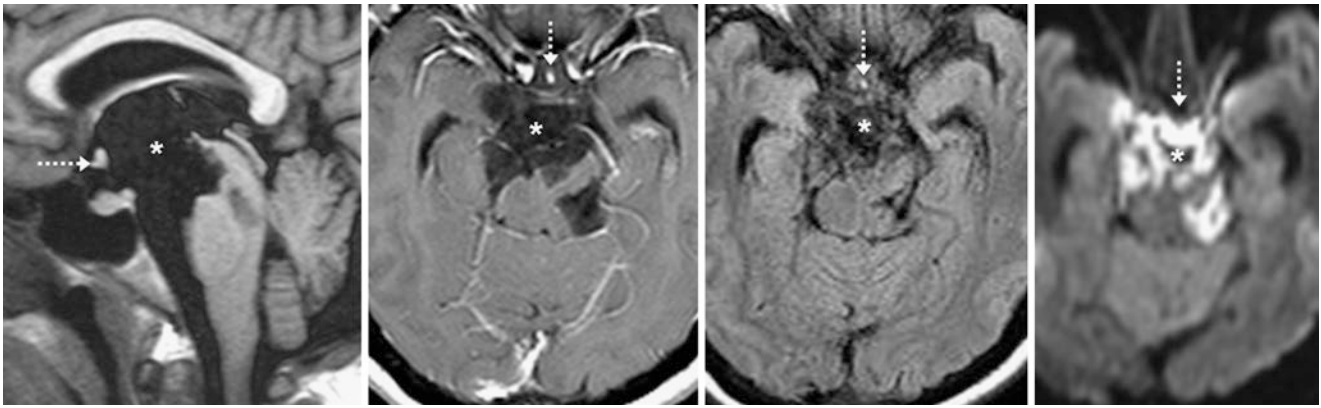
Comparison case of epidermoid cyst. A 40-year-old with multiple cranial nerve symptoms had a cyst (*) within the suprasellar cistern on 1-mm thickness sagittal reconstructions from a three-dimensional T1WI (left), axial postcontrast T1WI (left middle), noncontrast axial FLAIR (right middle), and DWI (right). The complex, non-CSF
